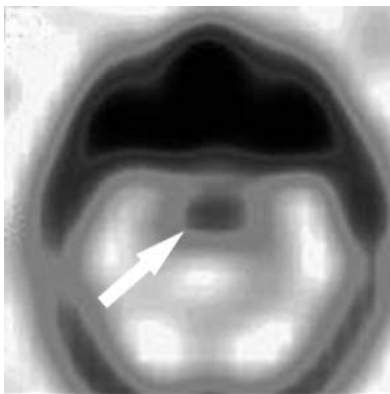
SPECT image of the pituitary gland. In the pituitary gland an area of an increased accumulation of  $^{99m}\text{Tc}$ -MIBI is shown (arrow)
